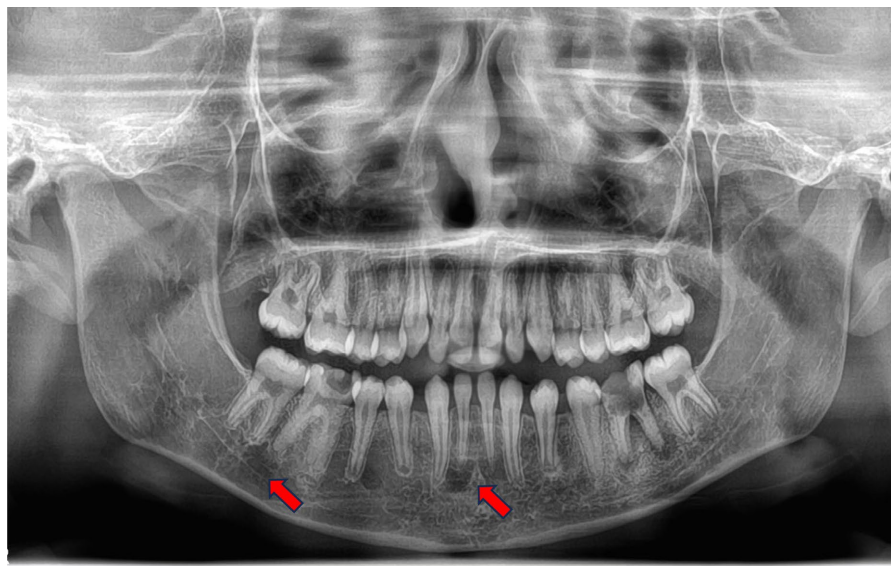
Panoramic radiograph of a sickle cell patient showing radiolucent areas. A panoramic radiograph of a 12-year-old child with sickle cell disease. The red arrows represent radiolucent images at the apical level of the teeth.
